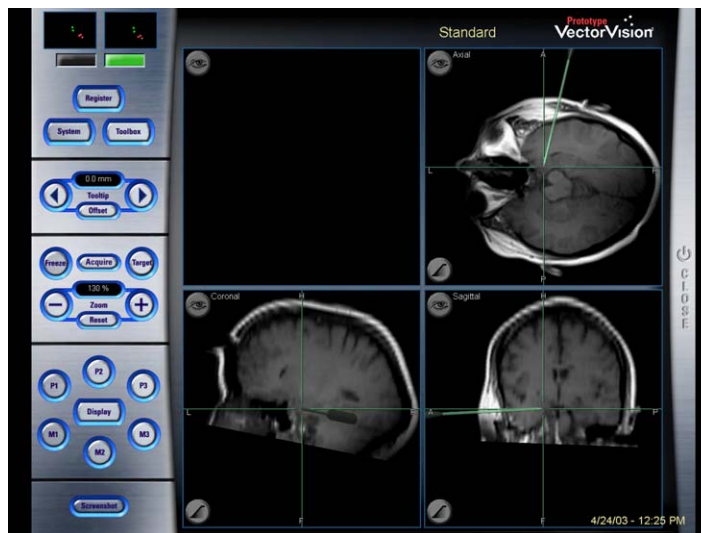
Intraoperative surgical planning T1-weighted MRI scans registered to a frameless navigation system (BrainLab, Redwood City, California). The screenshot demonstrates the surgical trajectory.
